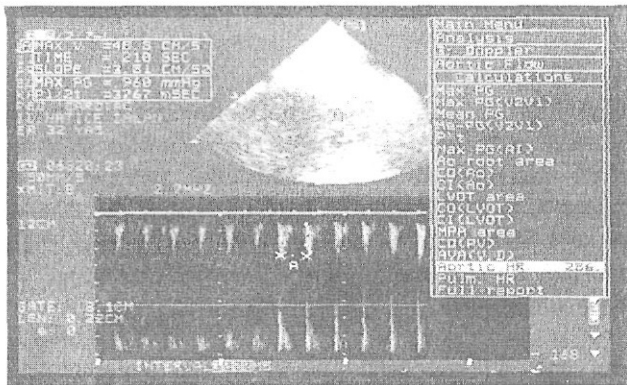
Fetal Doppler examination from the one of twin who has SVT
